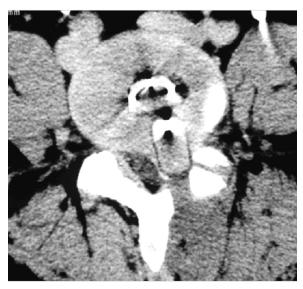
CT scan of posterior migration in the L4-L5 level
